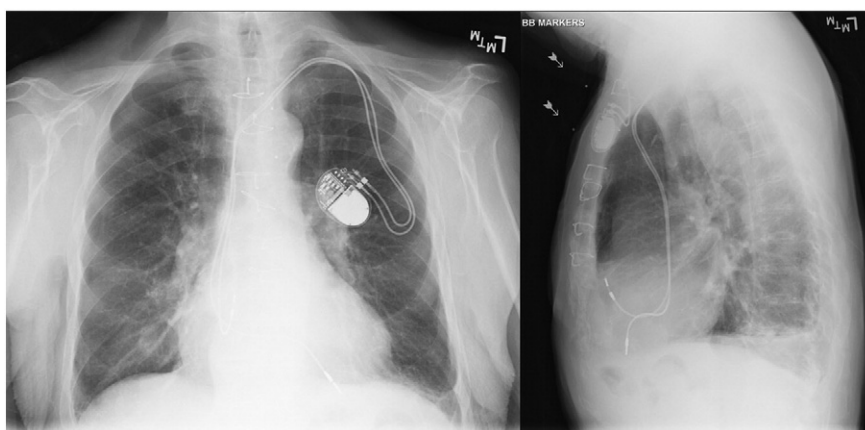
Posterioranterior (PA) and lateral chest x-rays (CXRs) highlighting sternal wires and permanent pacer wires. Temporary epicardial pacing wires are also present, but not discernible.
